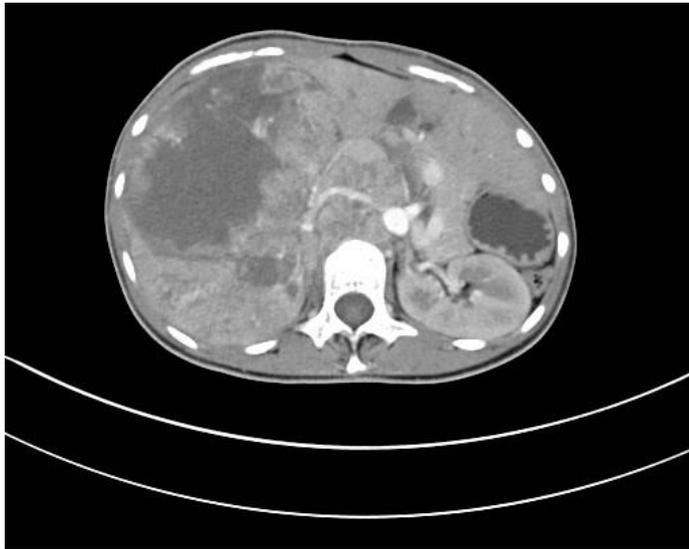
Baseline CT scan showing large partially cystic mass replacing right kidney
